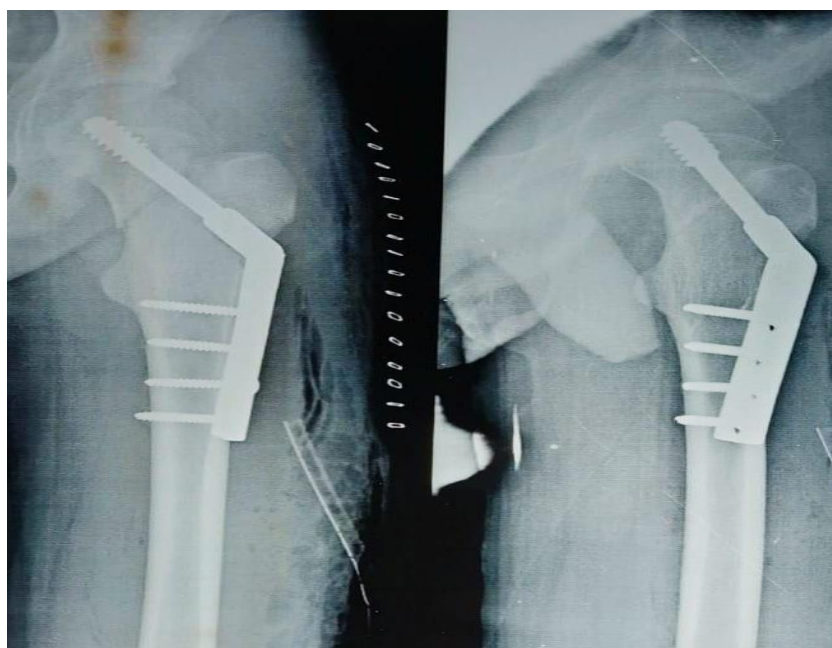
Xray of a vertical femoral neck fracture treated with dynamic hip screw with blade plate system.
